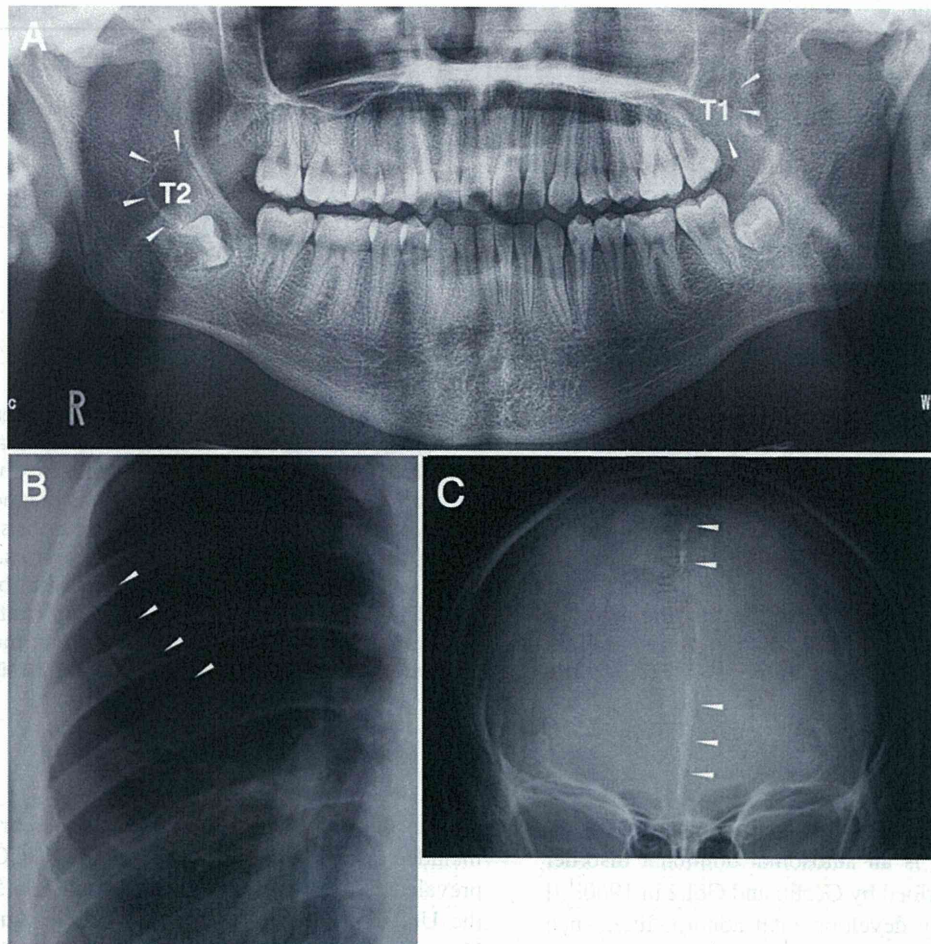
X-ray images of the patient. A, Two jaw cysts (arrowheads) were detected in the maxilla (T1) and mandible (T2) in a panoramic x-ray image. B and C, Bifid ribs (B) and calcification of the falx cerebri (C) were also observed (arrowheads).
